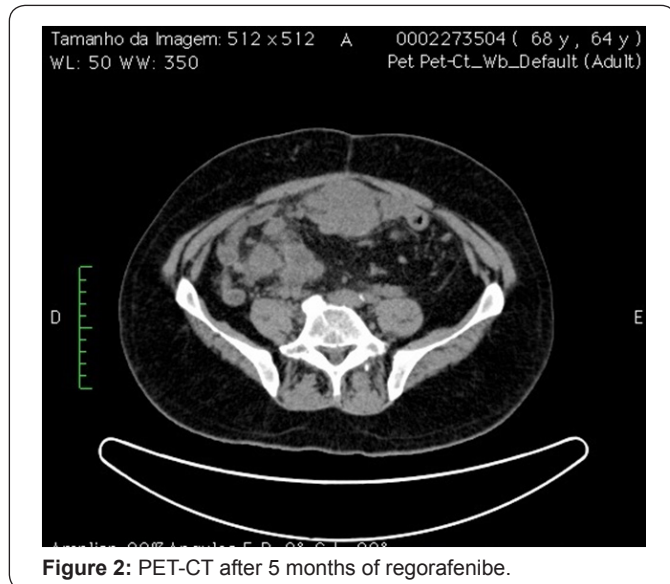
PET-CT after 5 months of regorafenibe.
